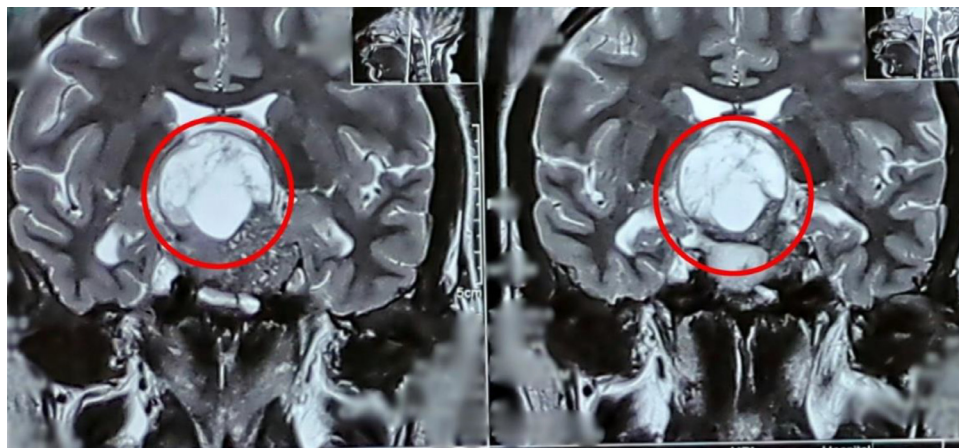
This image shows MRI scan of the brain in coronal T2-weighted images which reveals large suprasellar mass (marked by circles).
